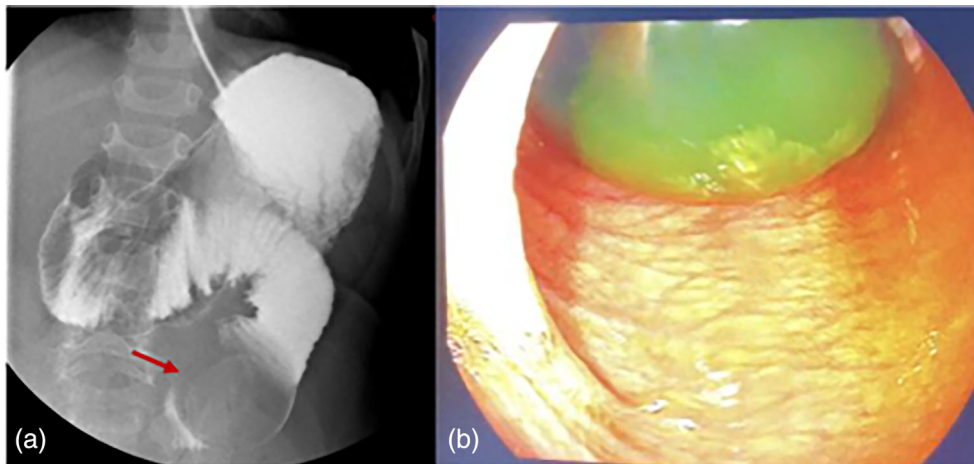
(a) Contrast upper gastrointestinal radiography: a radiopaque spherical image with a diameter of 3–4 cm in correspondence with the first jejunal loop (arrow), about 3 cm from the Treitz. (b) Endoscopy view: a large water bead obstructing the third portion of the duodenum.
